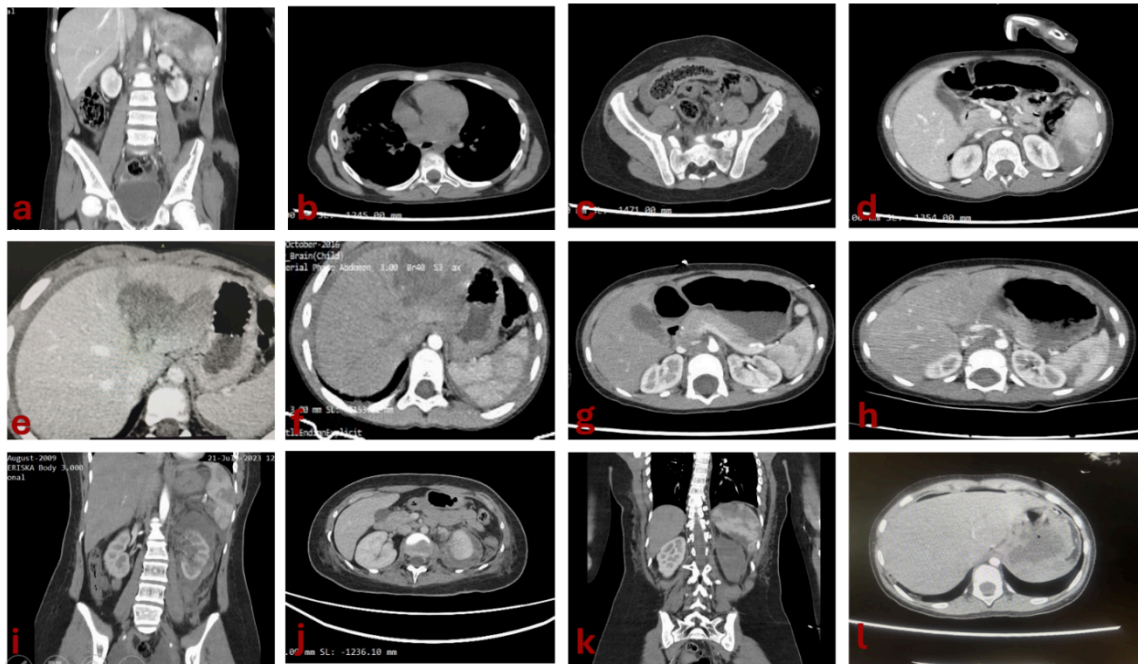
Contrast-enhanced abdominal CT demonstrating splenic injury patterns across five pediatric trauma cases.*
